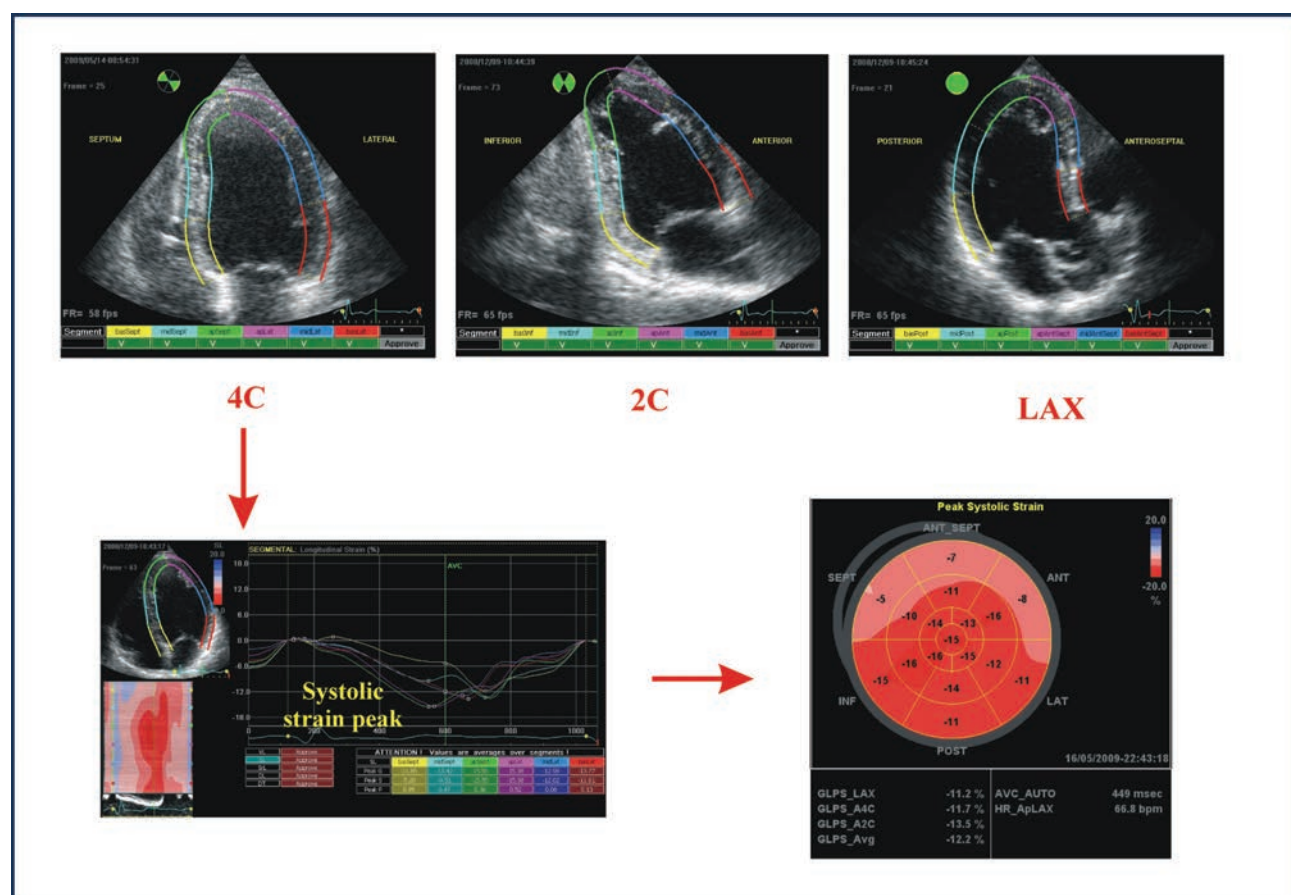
Global systolic strain evaluated by EchoPAC PC version (GE Vingmed Ultrasound, General Electric, Milwaukee, WI). Standard apical views acquired at a frame rate of 50-70 frame/sec are analysed by using 2D speckle tracking technique. GLS has been calculated as the mean values obtained in all the apical views.
